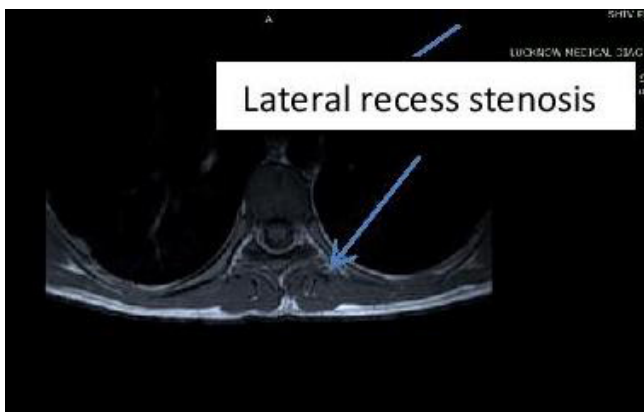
Axial view of MRI thoracic spine showing bilateral lateral recess stenosis
